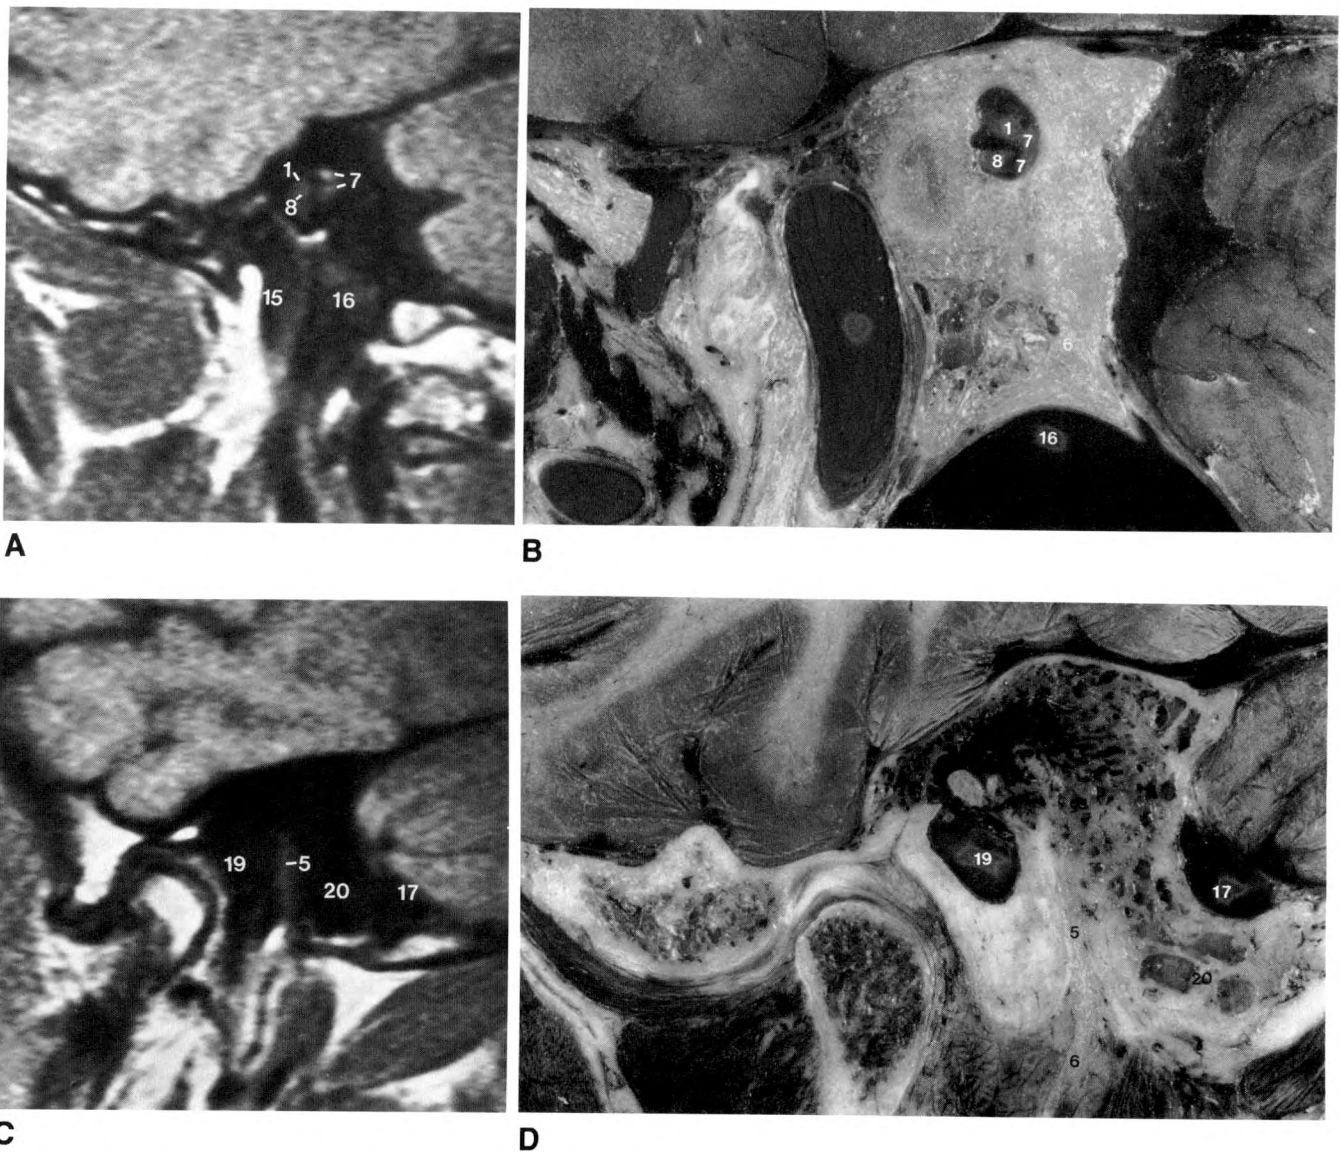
Sagittal MR images and cryosections.
